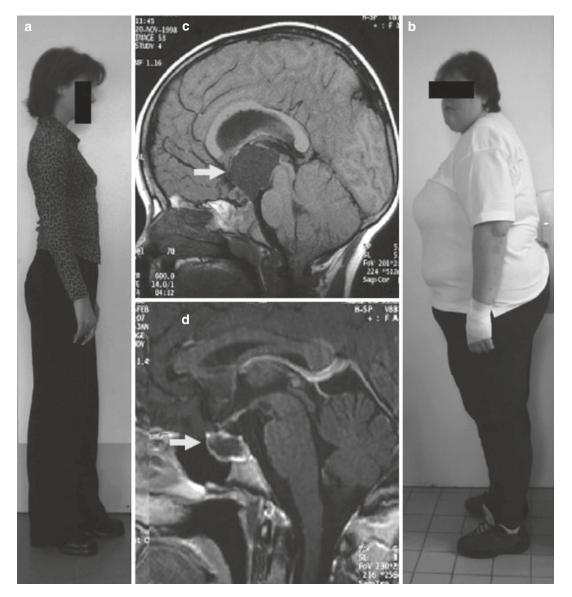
(a–d) Development of obesity and localization of craniopharyngioma. Postoperatively, both patients had panhypopituitarism. The patient seen in (a) had a small tumor revealed by magnetic resonance imaging (MRI) (d), which was removed transsphenoidally. Postoperatively, the patient continued to have normal eating behavior, and her weight developed normally (body mass index [BMI]: +1.0 standard deviation [SD]). The patient whose preoperative MRI (b) showed a large tumor extending to the suprasellar region and infiltrating the hypothalamus went on to develop an eating disorder and, consequently, obesity (BMI, +14.0 SD) (c) (Used with permission of Springer Science from Müller HL et al. Kraniopharyngeom im Kindesund Jugendalter. Monatsschr Kinderheilkd 2003; 151: 1056–1063)
